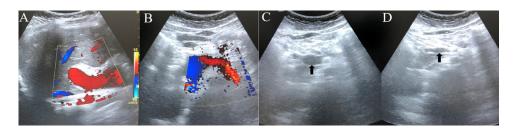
Doppler ultrasound images of PVA thrombosis at the 6-month follow-up after anticoagulant therapy. (A) Portal vein (17 mm) with positive hepatopetal flow. (B) Positive flow of the splenic vein to the portal vein. (C, D) The superior mesenteric vein (arrow), (C) before and (D) after applying transducer pressure, suggesting no thrombosis
